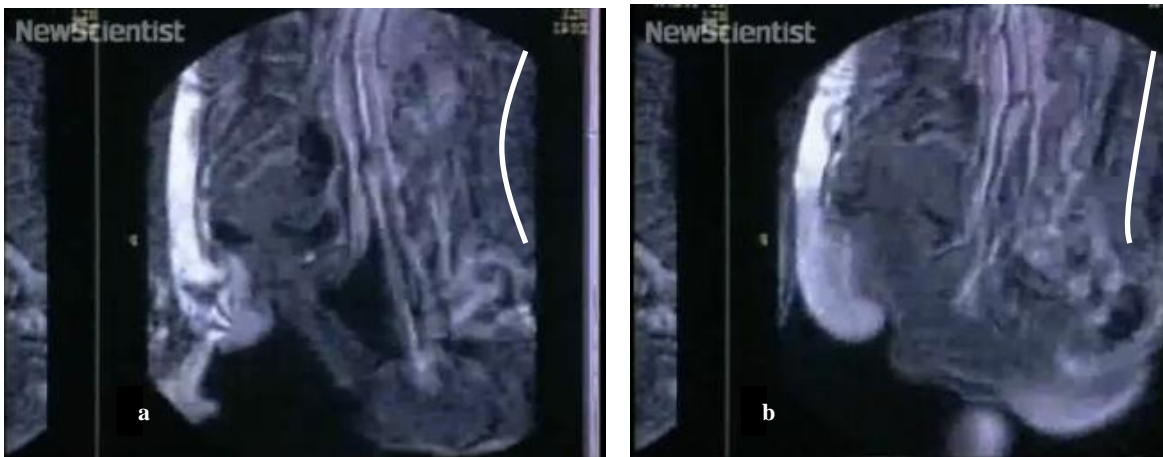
Midsagittal MRI image of the anatomy of sexual intercourse at the beginning (a) and end (b) of the penetration cycle. (New Scientist [updated 2009]). Note the white line, which roughly estimates lumbar spine curvature at the beginning (more extended) and end (more flexed) of the penetration cycle.
